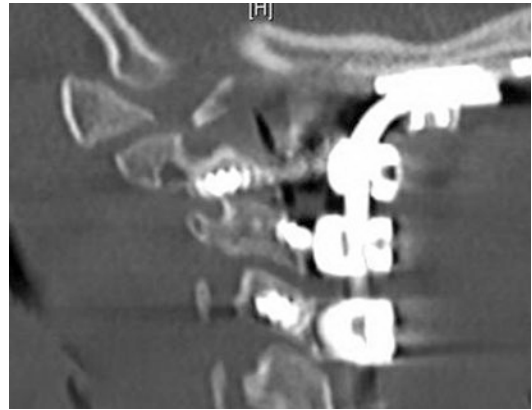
C4 lateral mass screws lateral CT
